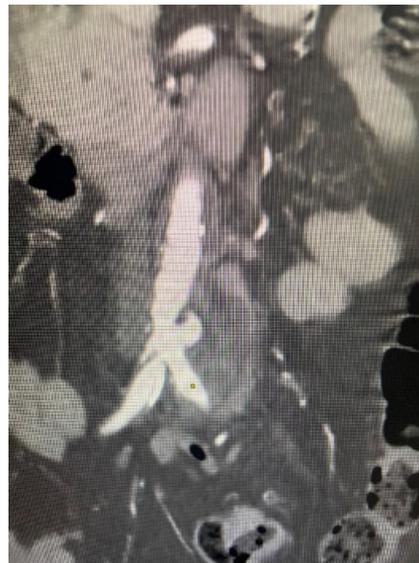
CTA- Saccular Aortic Aneurysm with collection
